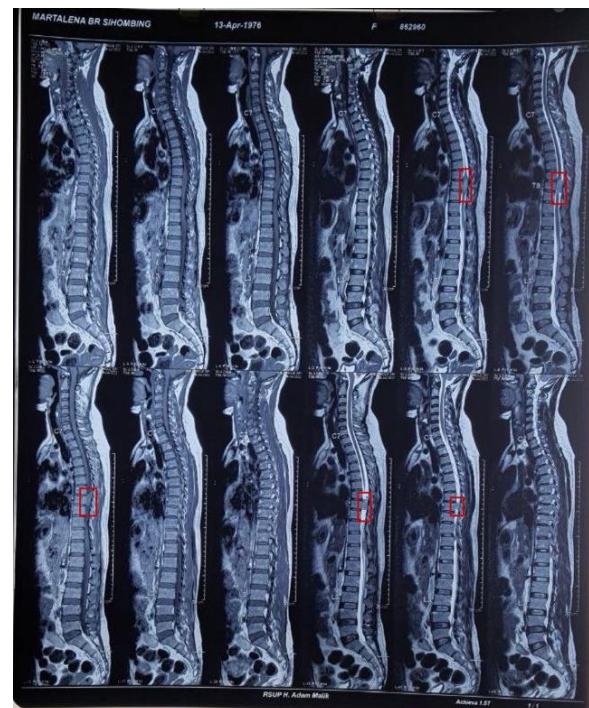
Pre-operative imaging by MRI of the whole spine on sagittal show SOL within the T7-T8 (on the red markers).
